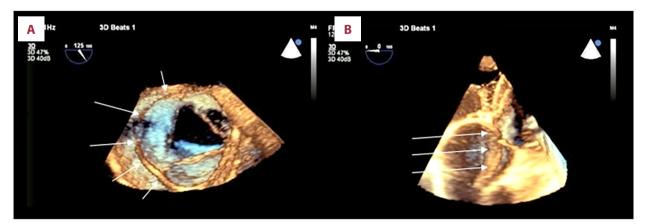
Three-dimensional transesophageal echocardiogram of the aortic valve. Short axis view (A) and modified 3-chamber view (B) demonstrating a dissection flap in close proximity to, and prolapsing across, the aortic valve (arrows).
